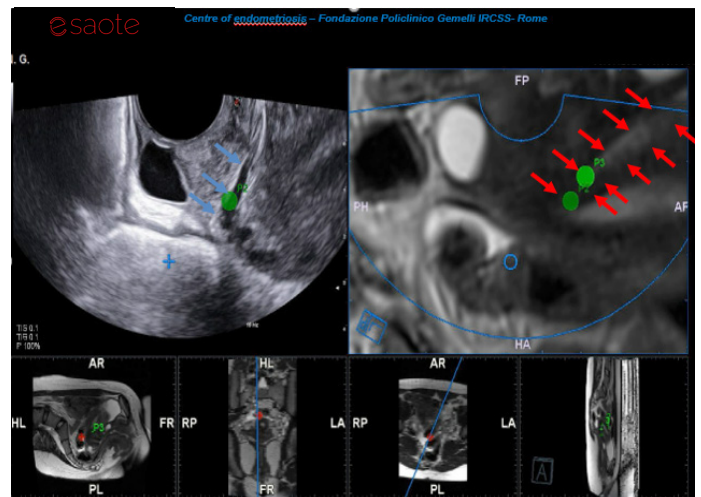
Fusion imaging between US (left) and MRI (right) in the sagittal plane. The blue arrows depict the ureter on ultrasound, while the red ones are the ureter on MRI. The blue marks (+/o) underline the synchronization between the two modalities. The green dots, P2 and P3, are located in correspondence of the dilated ureter.
